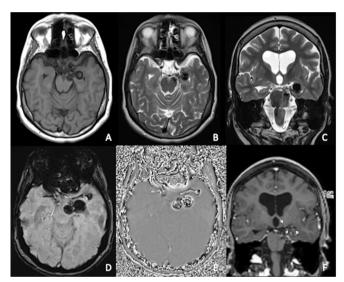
Magnetic resonance imaging shows multiple lobulated masses with low signal in T1-weighted (A) and T2-weighted (B and C images in the brain parenchyma and basal cisterns, with low signal in susceptibility-weighted imaging (SWI) (D) and phase images (E), compatible with calcifications. Lesions are non-enhancing in post-gadolinium images (F), except for a few peripheral enhancing foci (arrows), corresponding to small vessels.
